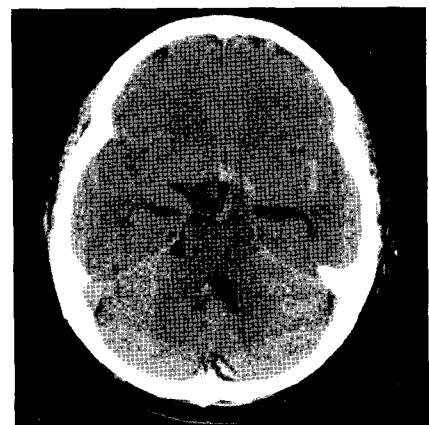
A brain computed tomography on admission demonstrating subarachnoid hemorrhage dominant in left sylvian fissure.
